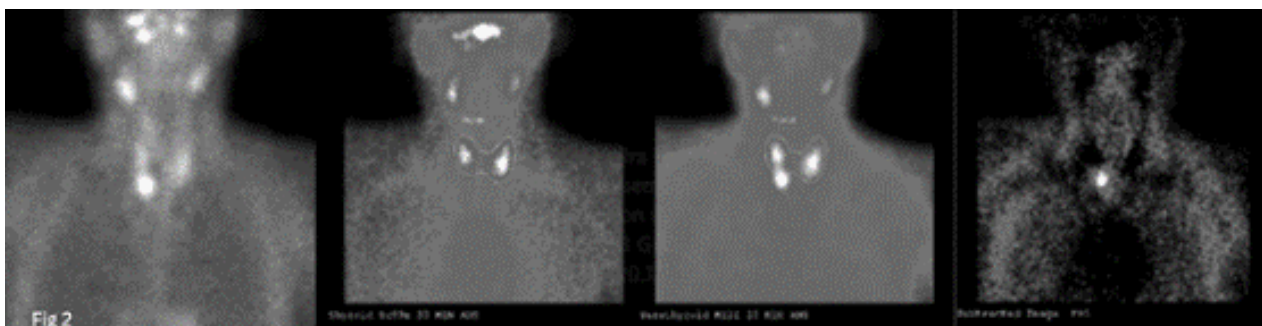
99mTc-sestamibi SPECT images of parathyroid scan, showing hyperfunctioning tissue inferior to the right thyroid lobe
